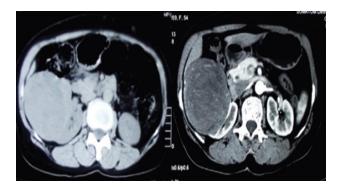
Cross-sectional CT scan images showing solid-cystic right renal mass.
